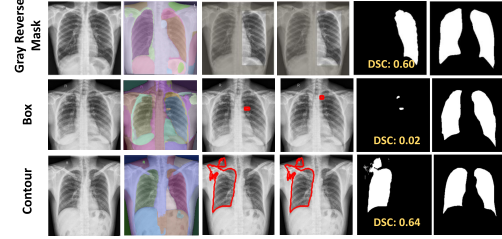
VPT results on X-ray labels and masks [19] dataset: Although SAM successfully generates masks for both lungs, VPTs do not facilitate CLIP in accurately retrieving ROIs.
